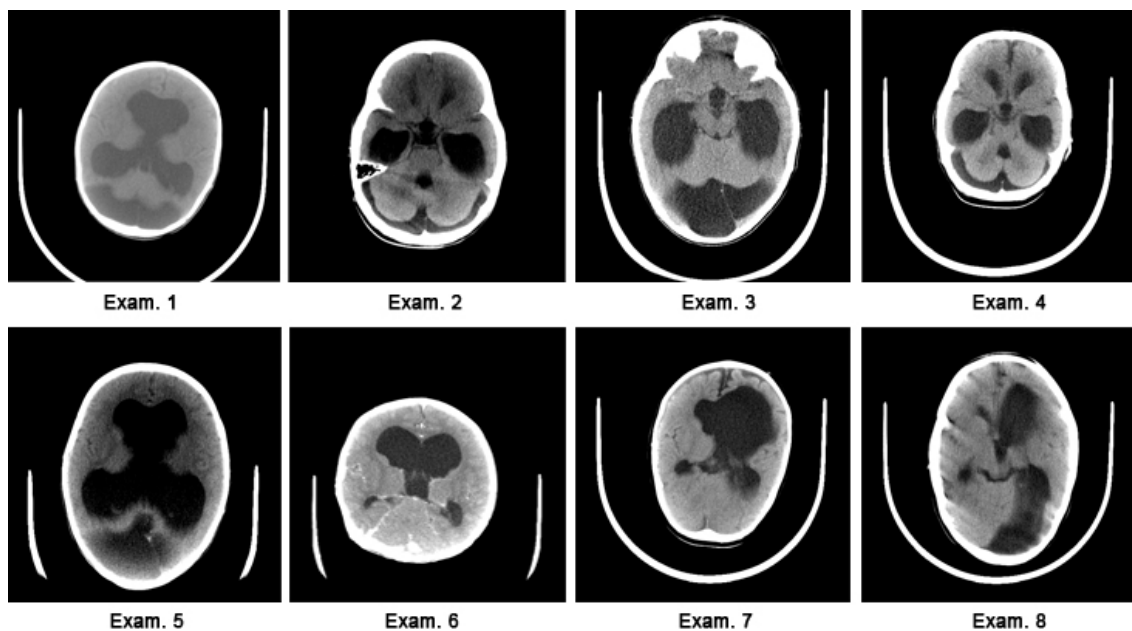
Single images from the CT datasets used in this research
